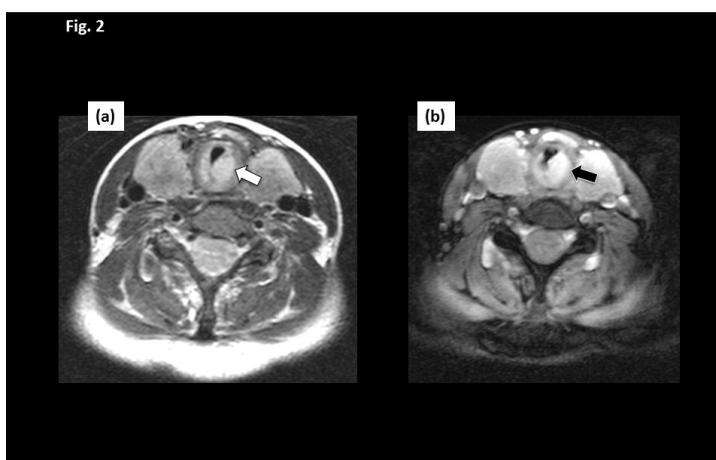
(a) MRI of the neck on T1-weighted images showed a well-defined intra-laryngeal hyperintense lesion (white arrow) causing occlusion of the airway. The native thyroid gland also appeared enlarged. (b) MRI of T1-weighted post gadolinium images showed avid enhancement of the intra-laryngeal lesion (black arrow) and also enhancement of the thyroid gland
